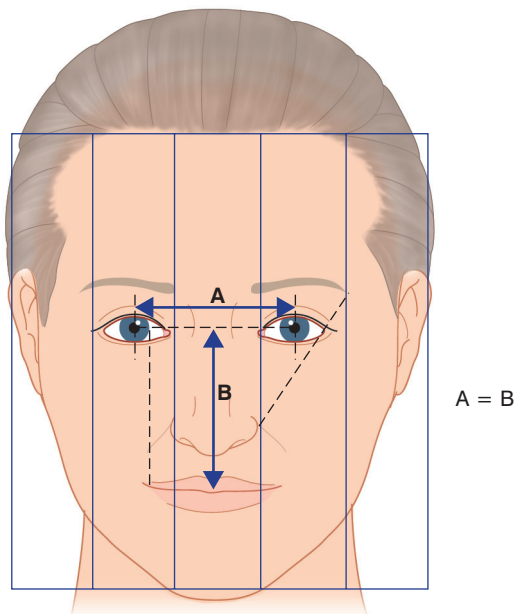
Central facial relationships. (After Salasche SJ, Bernstein G, Senkarik M. *Surgical anatomy of the skin*. Norwalk, CT: Appleton & Lange; 1988, with permission of The McGraw Hill Companies Inc ©.)
